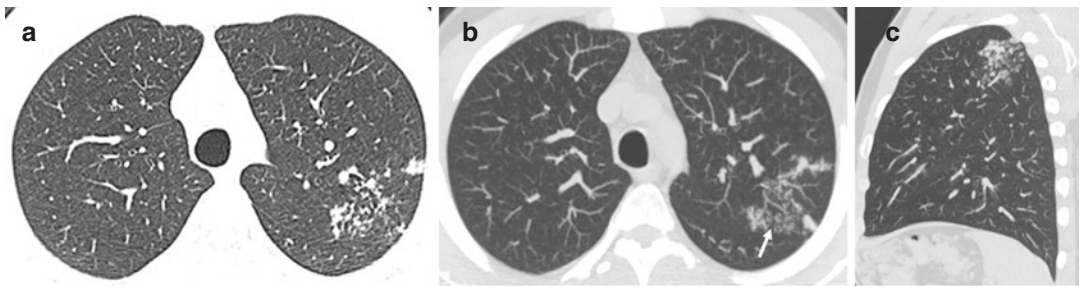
Post-primary tuberculosis in a 32-year-old man. (a) Axial HRCT and (b) axial and (c) sagittal MIP-reconstructed HRCT images show centrilobular
